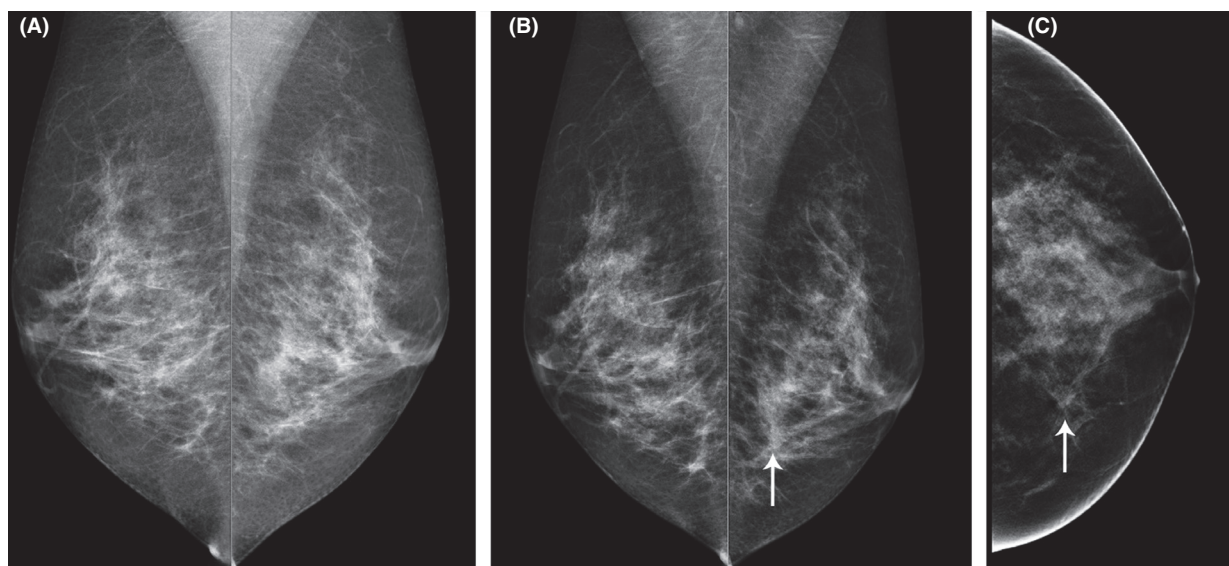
Left oblique mammograms: (A) prior study in 2013; (B) routine surveillance study 15 months later, 8 months after the MRI study shown in Figure 8; and (C) tomosynthesis left breast CC projection. A stellate mass (arrow) is now visible in the lower inner quadrant of in the left breast. Clinical examination was normal.
